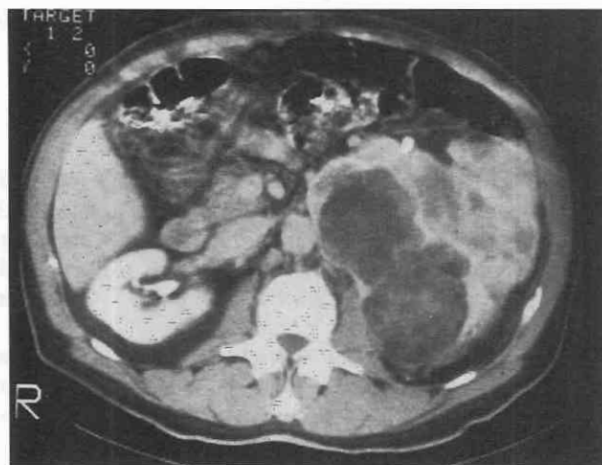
Liposarcoma. Nondynamically enhanced CT scan shows a huge liposarcoma demonstrating heterogeneous attenuation. The tumor contains components that show fat and soft tissue attenuation.
